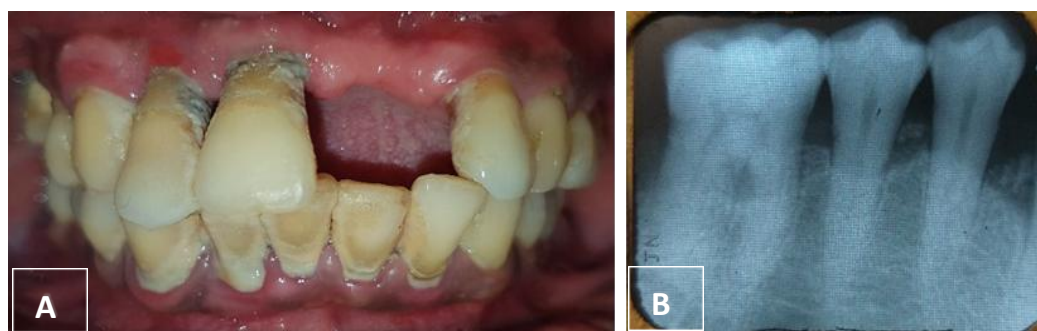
Pre-operative; A. Intraoral clinical, B. Periapical radiographic
